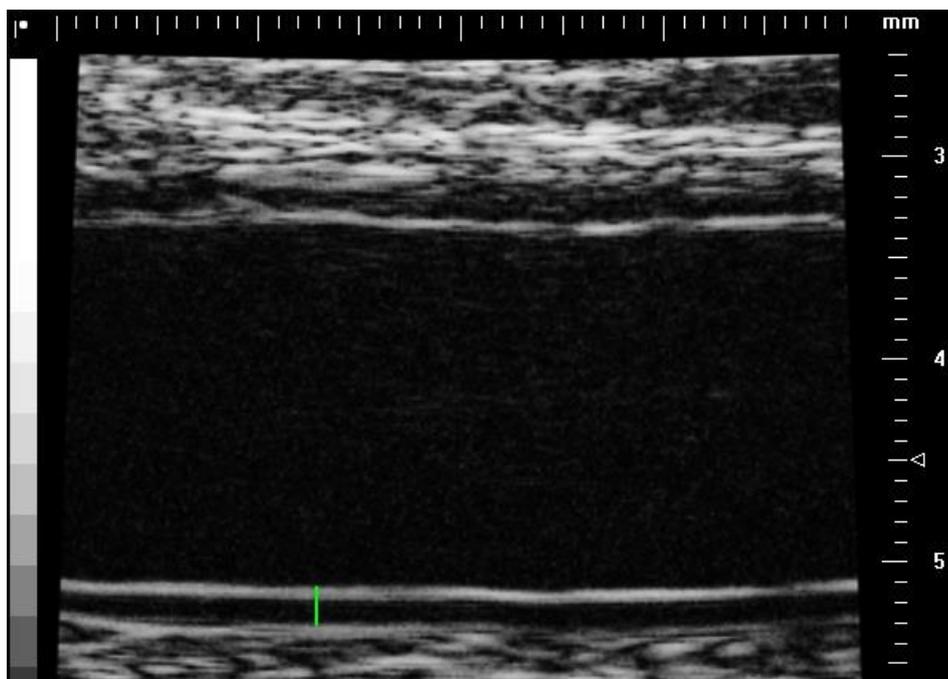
2D image of the right radial artery obtained by high-frequency ultrasound. The black color represents the blood. The green mark represents the IMT.
